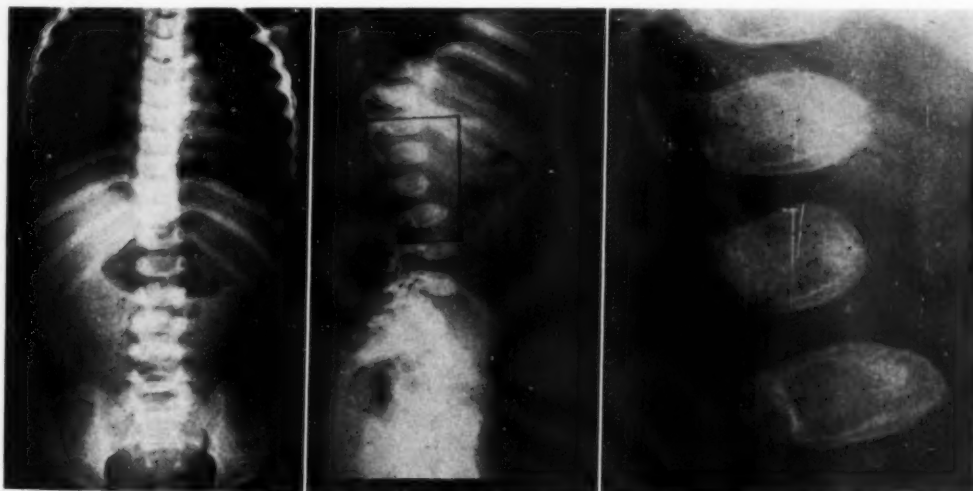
Abnormal contour of the vertebral bodies. Films of the lumbar spine four years after the initiation of roentgen therapy for inoperable neuroblastoma in a four-month-old infant. The calculated incidental dose to the body of L-2 was 2,726 r in twenty-four days and, eight months later, 396 r in nineteen days.
